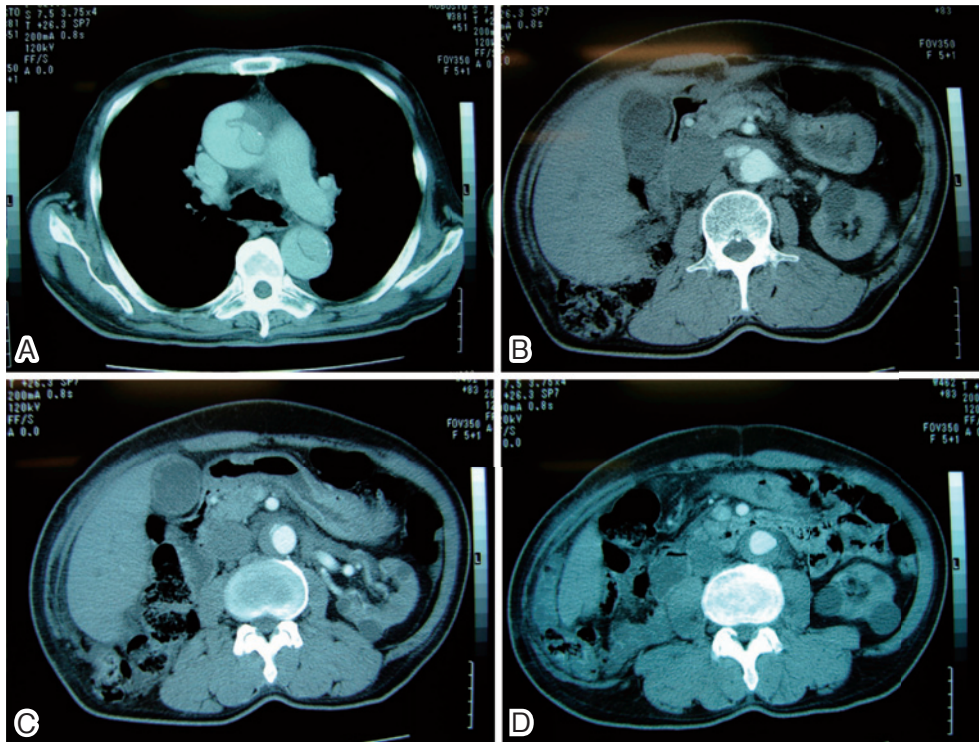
A: CT on admission showed acute type A aortic dissection extending from the aortic root to the level of the infrarenal arteries. B-D: CT also revealed 5 or more cysts in the left kidney.
